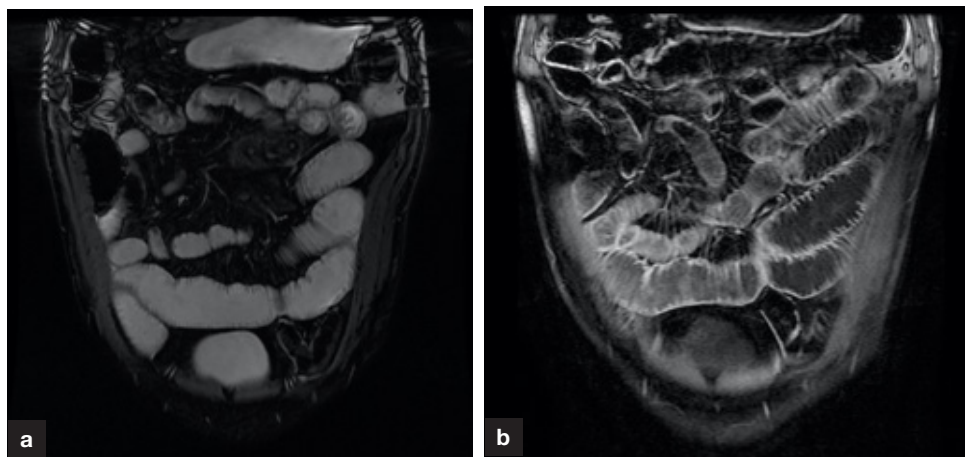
Magnetic resonance images ((a) coronal FIESTA FAT-SAT and (b) coronal post-contrast) demonstrating the typical 'hide-bound' appearance of the small bowel (narrowly separated valvulae conniventes) in scleroderma.
